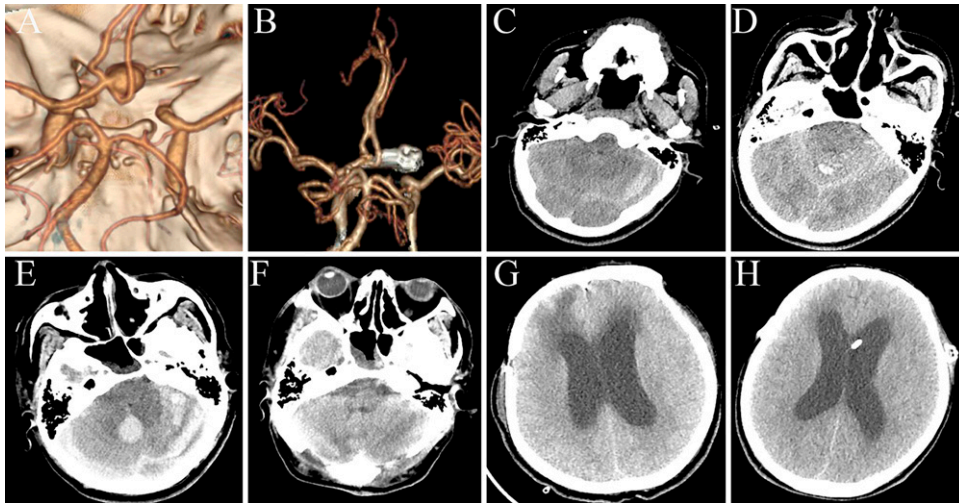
A: Preoperative computed tomography angiography (CTA) examination revealed anterior communicating aneurysm. B: Postoperative CTA examination showed that the aneurysm was completely clipped. C and D: Cranial CT scan 12 hours postoperatively revealed a small amount of hematomas in both left cerebellar hemisphere and vermis. E: At 36 hours postoperatively, CT scan showed increased hematoma in the left cerebellar hemisphere and vermis. F: CT scan 10 days after posterior fossa decompression showed improvement in brain swelling. G: Cranial CT follow-up at 1 month postoperatively revealed hydrocephalus with interstitial cerebral edema. H: Cranial CT follow-up revealed improved hydrocephalus and interstitial cerebral edema after ventriculoperitoneal shunt.
